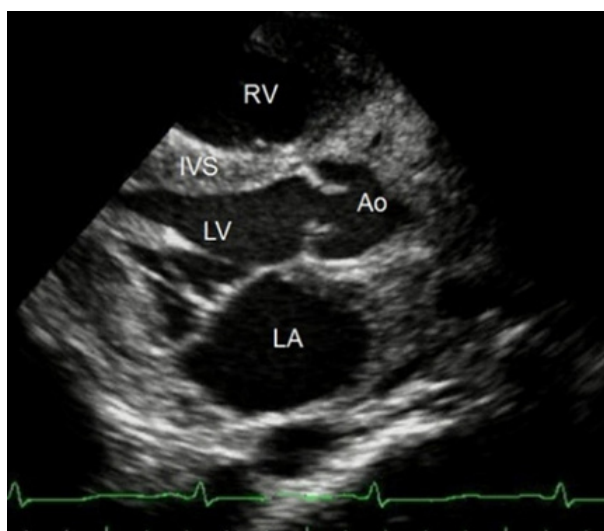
Pre-chemotherapy transthoracic echocardiography in parasternal long and short axes view showed diffused leukemic infiltration of the left ventricle posterior wall, interventricular septum, interatrial septum, left atrium (LA) and right atrium wall, right ventricle outflow tract, ascending aorta and main pulmonary artery wall.
